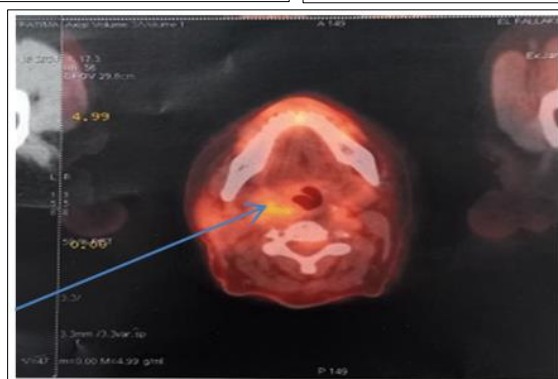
PET scan Pet-Scan 18-FDG: image of retro pharyngeal ADP magma.
